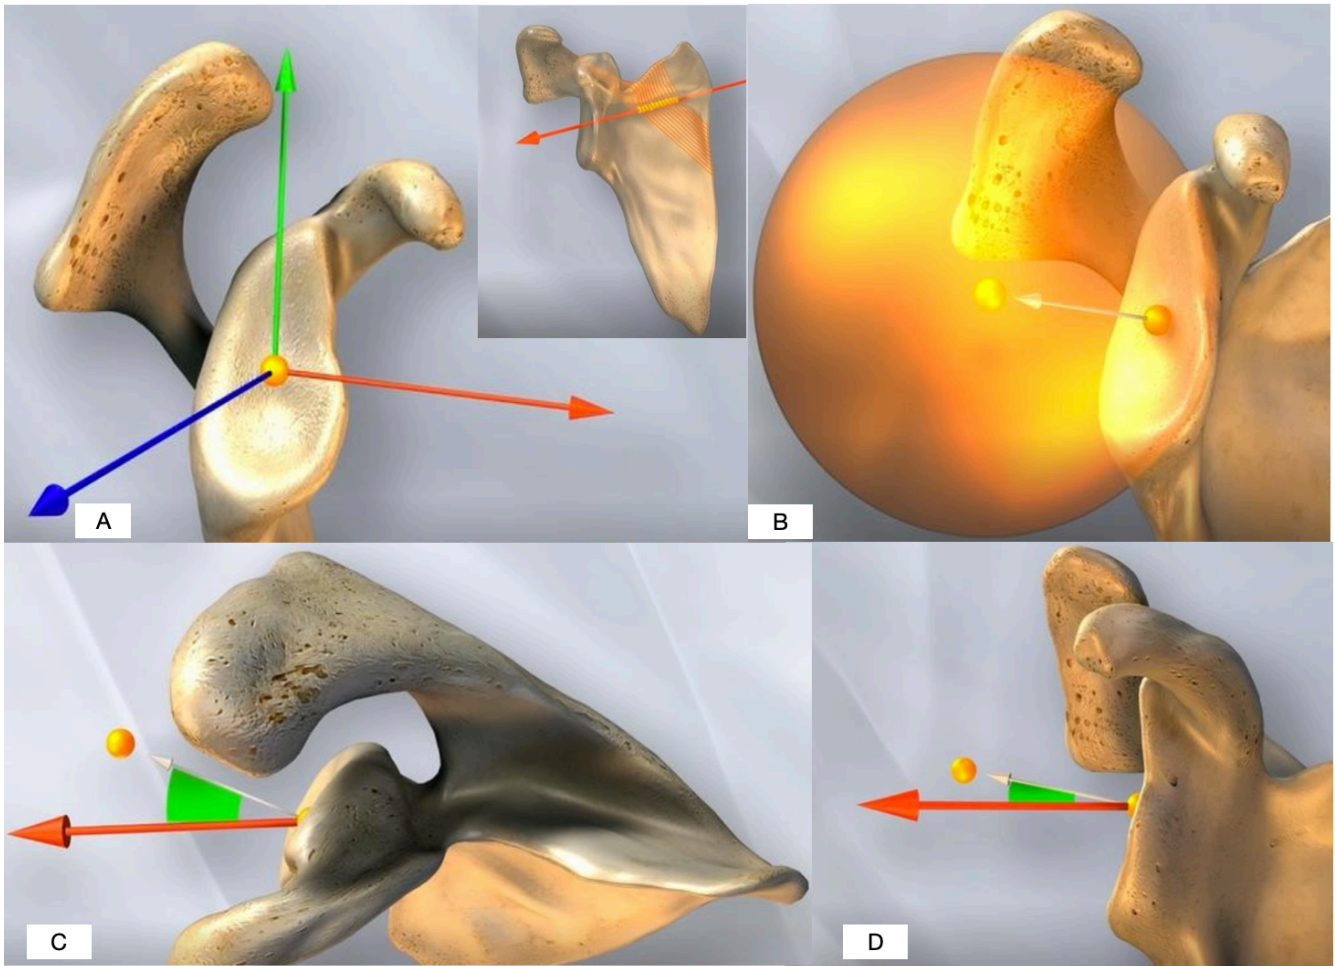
Preoperative 3D software planning used in this study. The system automatically 3D segments CT scan series. A) an orthogonal coordinate system is created after a previous identification of scapular and transverse axes, B) the software then extrapolates a best-fit sphere from the articulating data points, where a radius is drawn from the center of the best fit sphere to the center of the glenoid, C) glenoid version is identified in the axial view as the angle between the transverse axis and the radius of the best fit sphere in the anterior-posterior direction, D) glenoid inclination is identified in the coronal view as the angle between the transverse axis and the radius of the best fit sphere in the superior-inferior direction.
